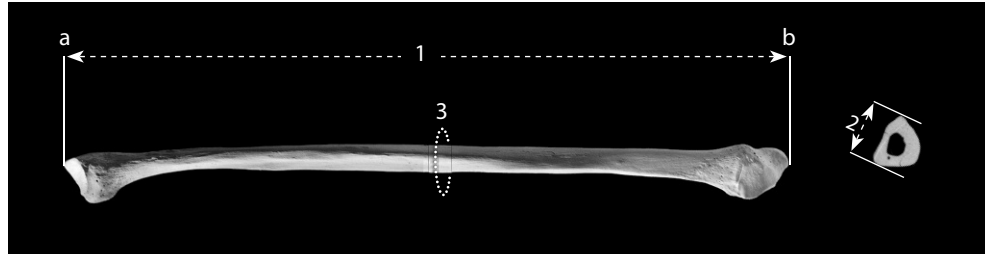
Fibular measurements. One-fourth (bone) and one-half (CT scan) natural size.
